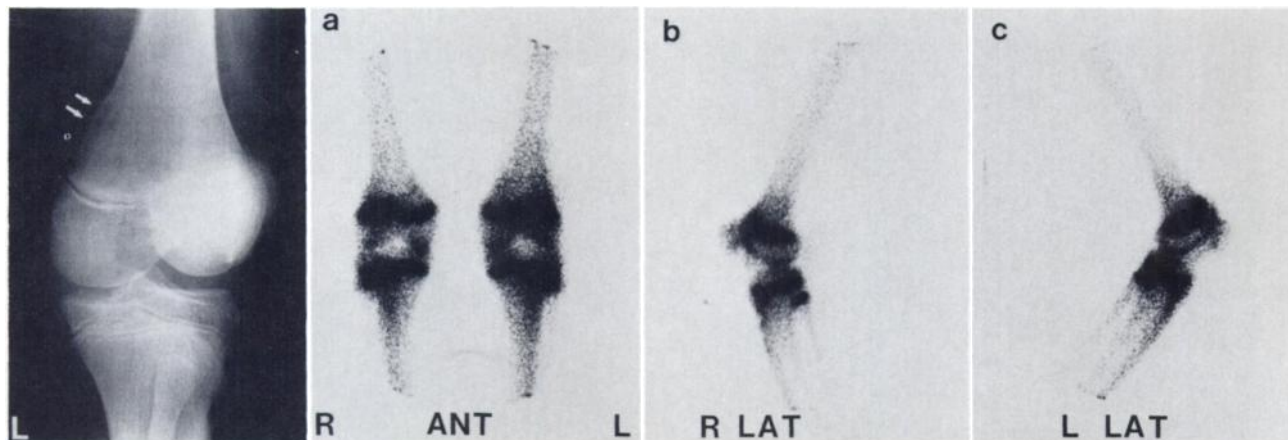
Case 2: Oblique AP radiograph with 30° of external rotation demonstrating cortical irregularity and periosteal elevation along posterior medial aspect of distal left femur. Bone images with (a) anterior, (b) lateral projection of right knee, and (c) lateral projection of left knee demonstrating slightly increased activity diffusely in left knee.
